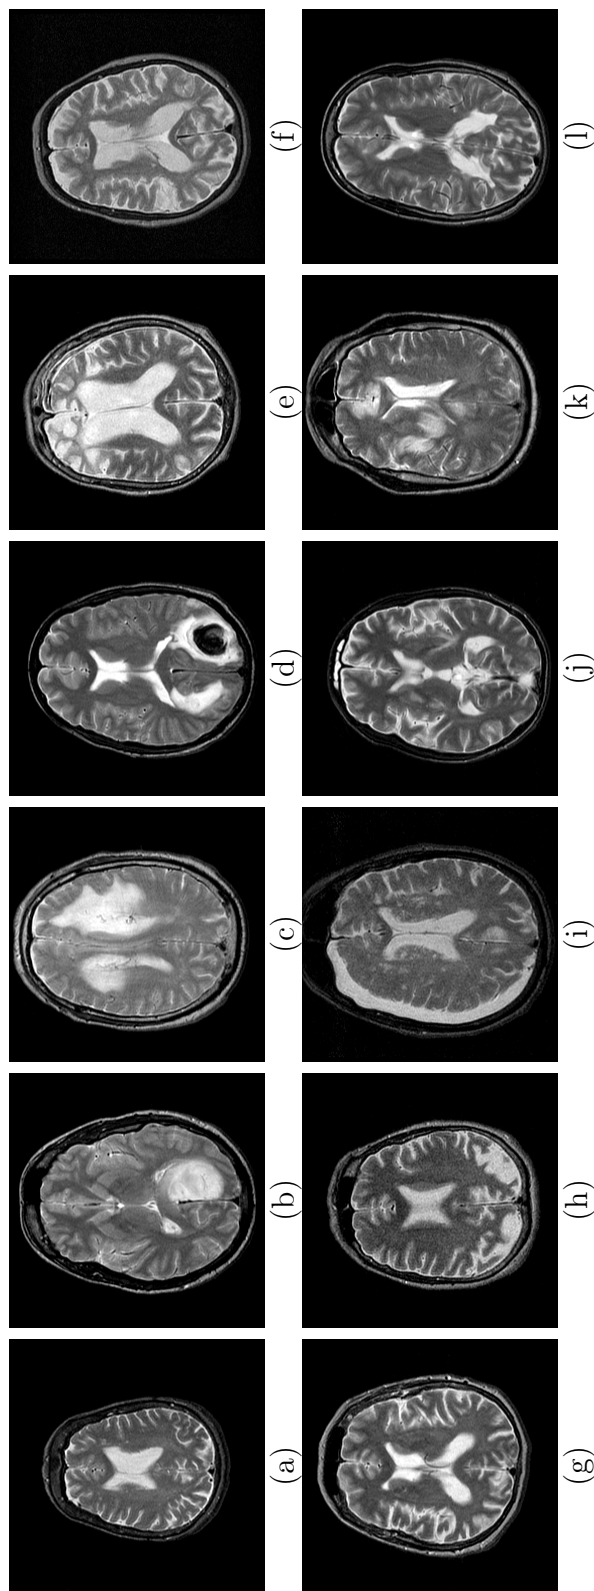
Sample brain MR images used in the experiments of 'Scheme 1': (a) normal, (b) glioma, (c) meningioma, (d) sarcoma, (e) Pick's disease, (f) Huntington's disease, (g) Alzheimer's disease, (h) Alzheimer's disease with visual agnosia, (i) chronic subdural hematoma, (j) cerebral toxoplasmosis, (k) herpes encephalitis, (l) multiple sclerosis.
